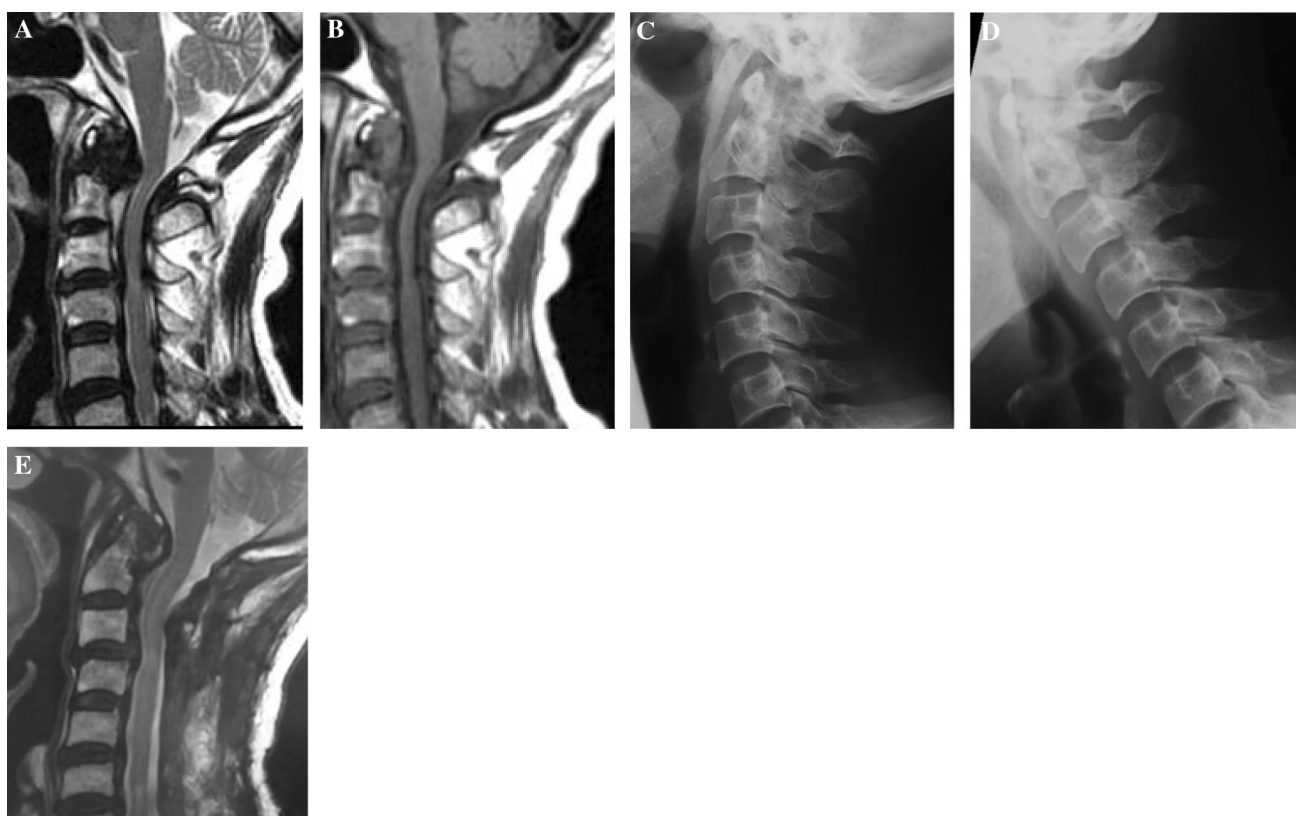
Case 2: a retro-odontoid pseudotumor detected on T2-weighted MRI. b Enhancement was not present on Gd-enhanced MRI. c, d Lateral extension–flexion radiographs did not show AAS (Δ ADI=2.2 mm). e Image at 1 year after surgery, showing no regression of the retro-odontoid pseudotumor
